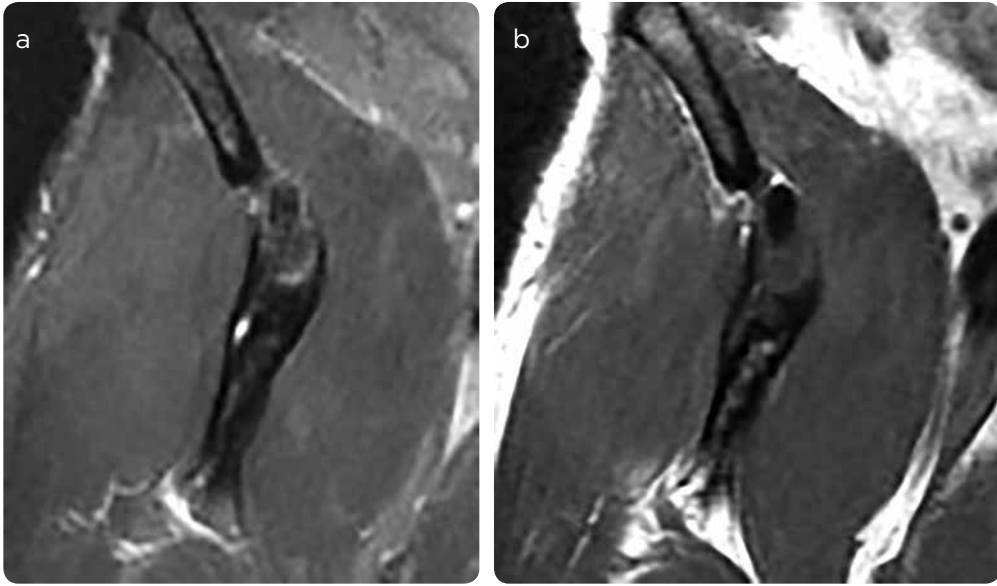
Coronal MRI cuts at right hip height: an ossified, linear image projected on the anterior soft tissues is observed, articulated with the anterior portion of the acetabular roof.
